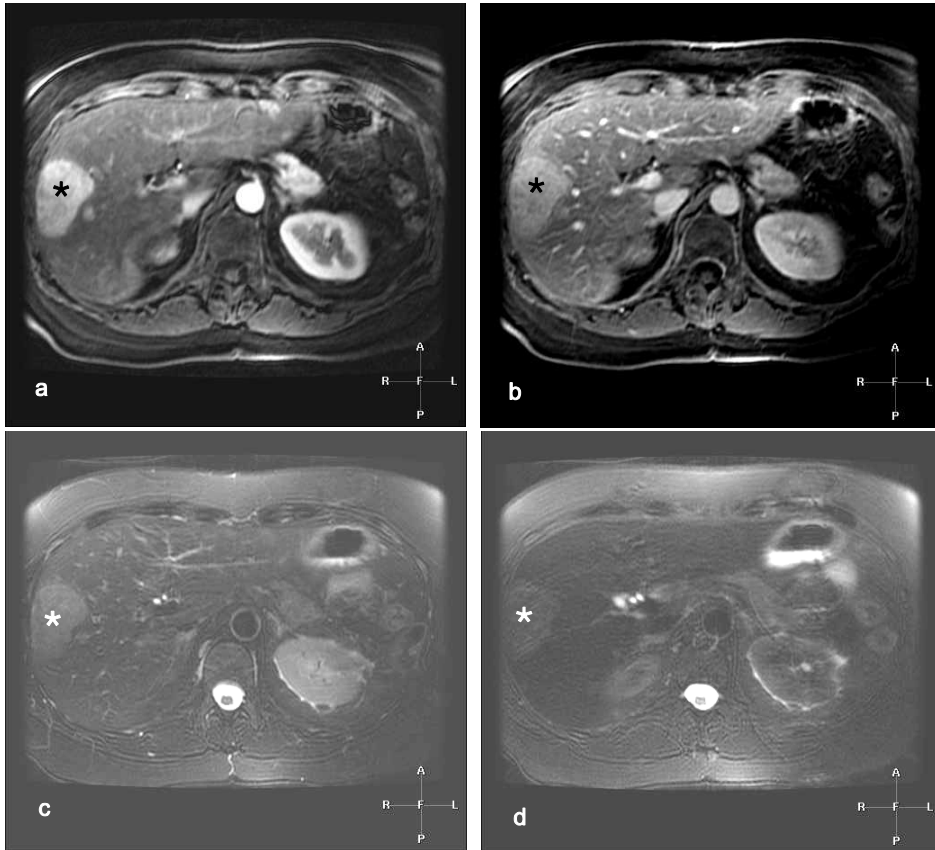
A 30-year-old woman (not described in this manuscript) with a tumour that shows MR imaging findings of a typical hepatocellular adenoma. a. A T1-weighted MR image during the arterial phase after intravenous Gadolinium injection shows a tumour with homogeneous enhancement of the entire nodule (*). b. A T1-weighted MR image with fat-suppression during the delayed phase after the injection of Gadolinium shows the tumour (*) that has become almost isointense with the surrounding liver, without any evidence of a tumour capsule. c. A T2-weighted MR image with fat-suppression before the intravenous injection of superparamagnetic iron oxide (SPIO) contrast agent that is specifically taken up by the Kupffer cells. The tumour (*) is slightly brighter than the surrounding liver, a typical sign of a benign hepatocellular tumour like adenoma. d. A T2-weighted MR image with fat-suppression after the intravenous injection of superparamagnetic iron-oxide contrast agent. Note that the liver has become substantially darker compared to the image shown in c) due to the SPIO uptake. In addition, the tumour (*) also shows homogeneous decrease in signal intensity indicating that the tumour contains Kupffer cells with homogeneous distribution, suggesting the primary and benign nature of this lesion.
